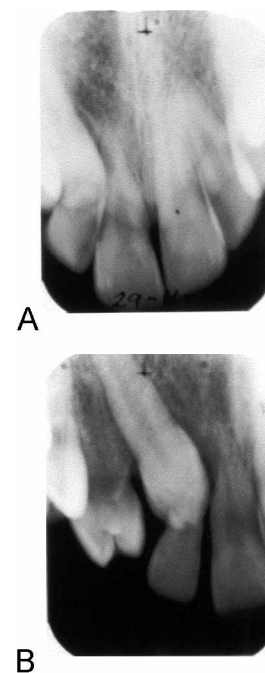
Two radiographs from the same patient (case no. 5) aged 13 years and 2 months. The supernumerary tooth was located adjacent to 11 and was surgically removed at age 6 years and 7 months. The figure demonstrates ectopic eruption of 13. A. Mesial projection shows that 13 resorbs the root of 12. Pulp deviation occurs in 11. B. Distal projection shows that 13 also resorbs the root of 11. Pulp deviations occur in 11 and 21.
